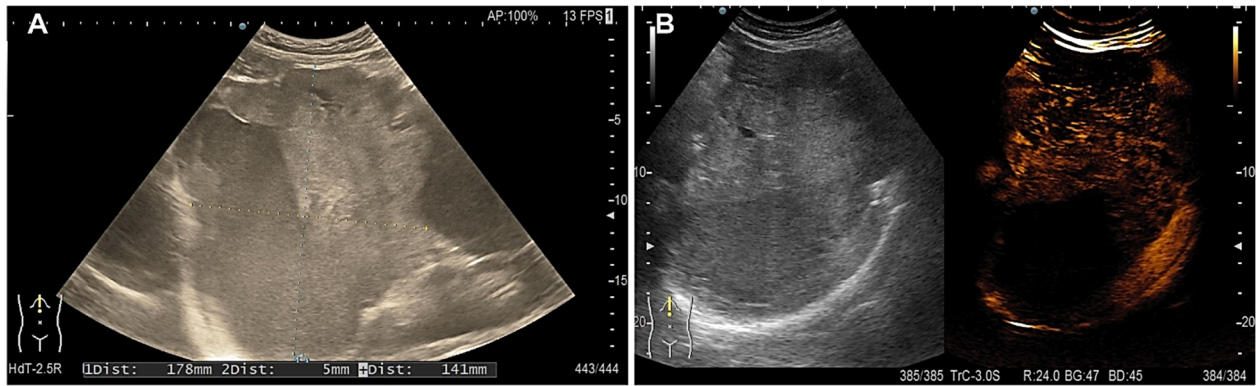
(A) US image of the tumor as a heterogeneous mass with tissular and cystic component extended from left liver lobe to the spleen's hilum; (B) CEUS showed unenhanced areas represented by the cystic and necrotic components, while the tissular part of the tumor was enhanced in the arterial phase with secondary wash out in the late phase. CEUS: Contrast-enhanced ultrasonography; US: Ultrasound.
